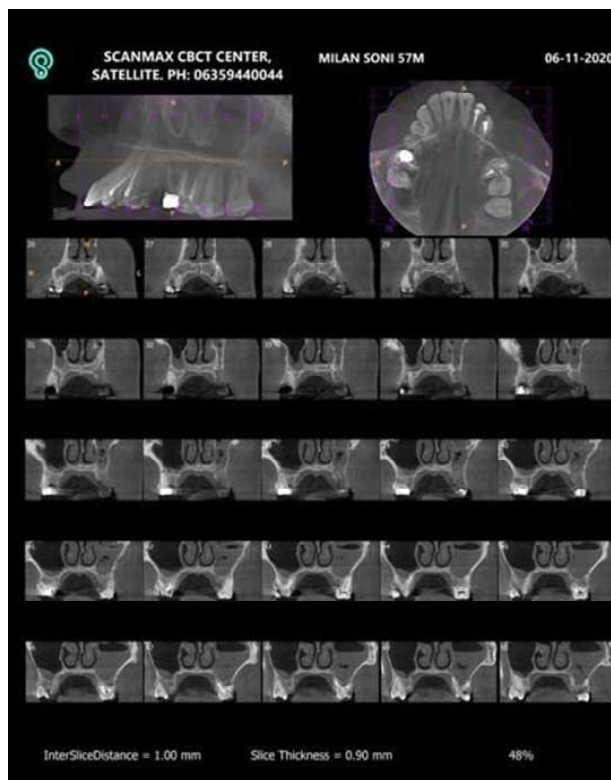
CBCT findings as congestion of right side maxillary sinus
